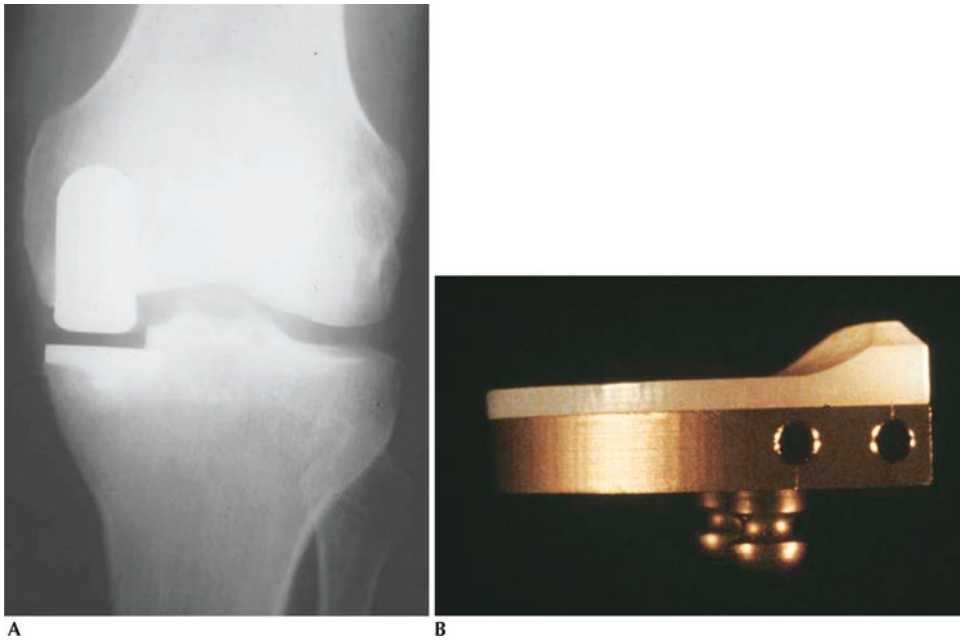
(a) Radiograph of second-generation metal-backed tibial UKA. (b) Metal-backed tibial implant demonstrating the thin polyethylene at the peripheral margin of the implant
